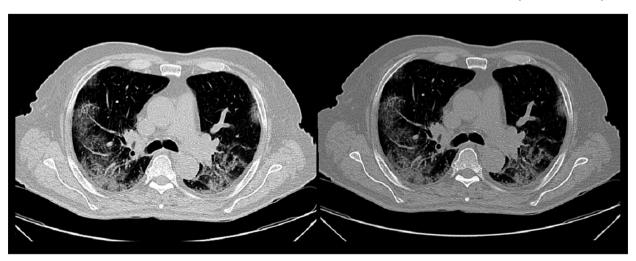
Chest computed tomography scan showing bilateral ground-glass pulmonary infiltrates.
